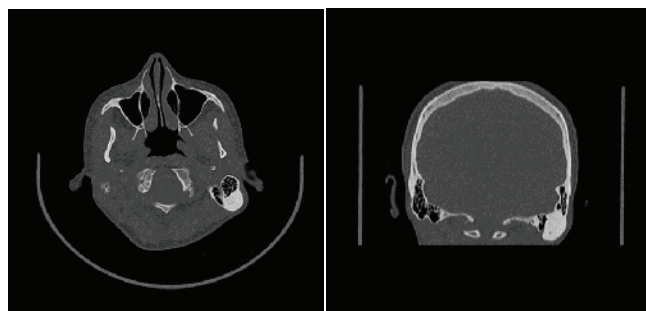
CT axial and coronal slides.
